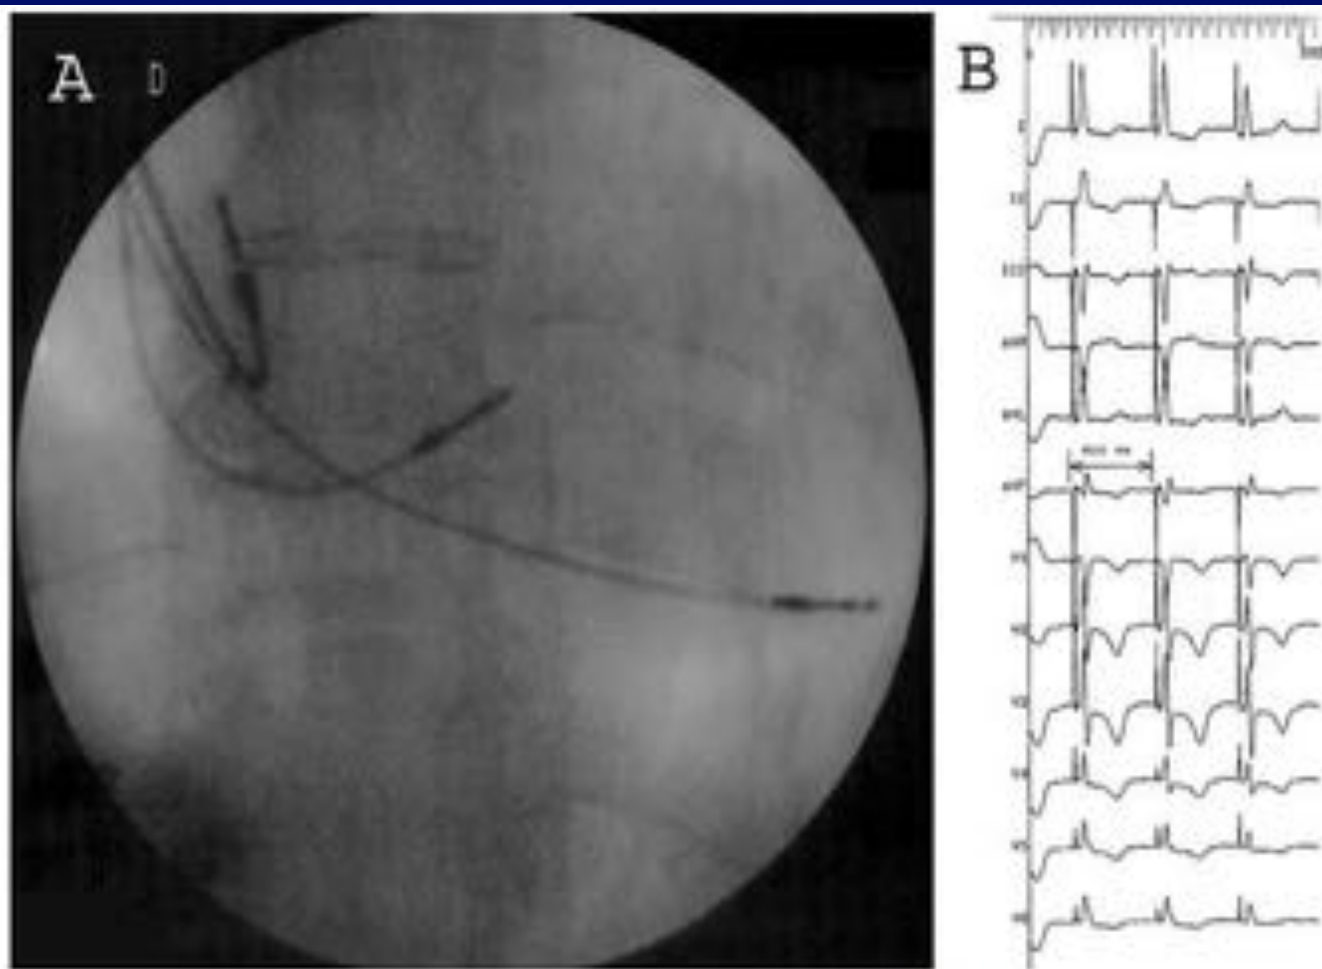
Panel A: PA x-ray showing the final position of the right atrial, right ventricular, and His bundle leads. Panel B: Continuous pacing at the final position of the His bundle lead catheter beside the reference temporary catheter, the third complex is a pure His bundle capture, while the other two QRS complex are minimally fused.
